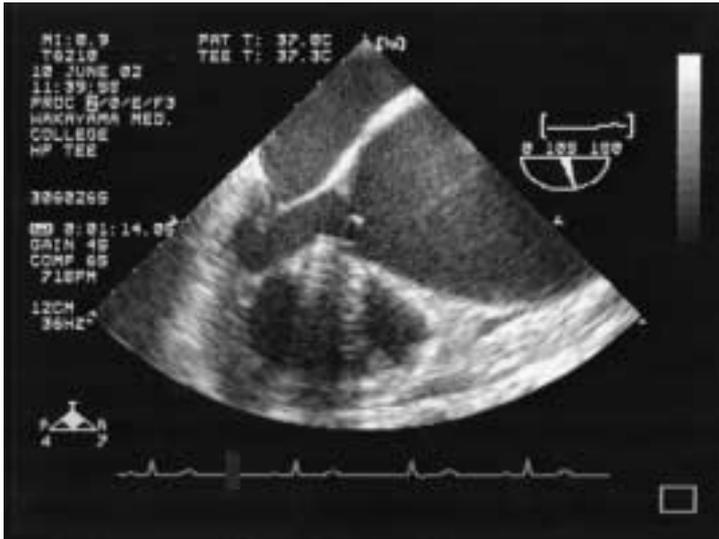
Preoperative transesophageal echocardiogram (TEE). TEE demonstrated an ascending aortic aneurysm without annular dilatation. Doppler echocardiographic study demonstrated moderate aortic regurgitation.
